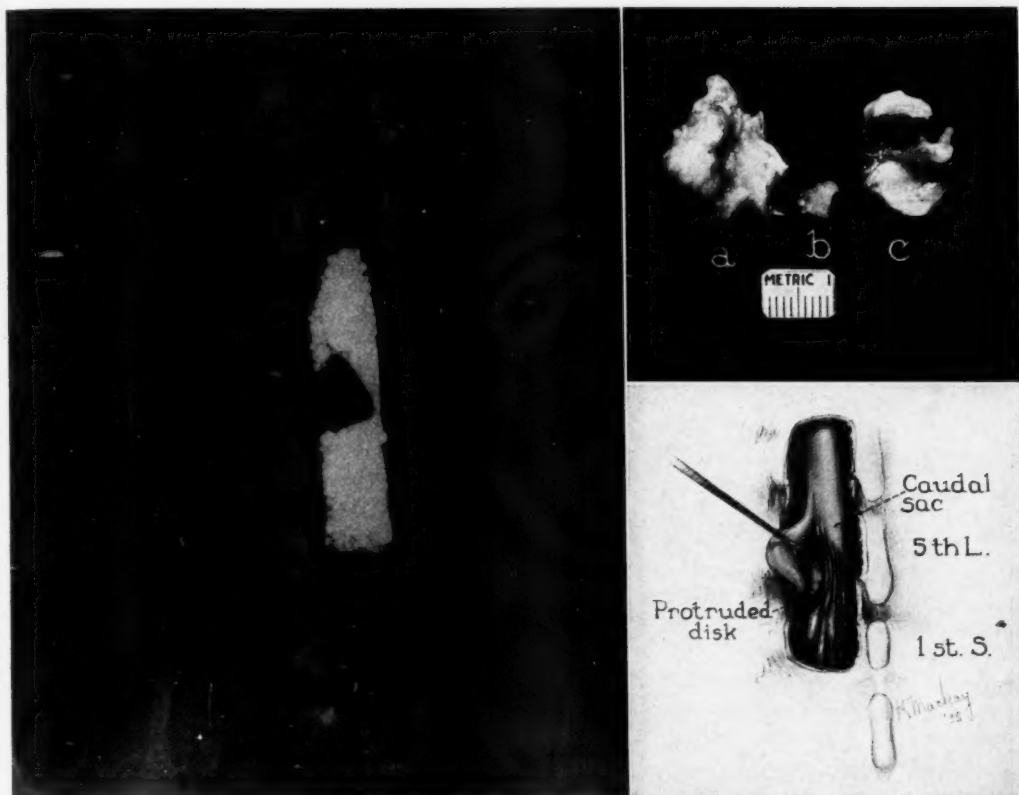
(left). Postero-anterior roentgenogram showing defect in the column of lipiodol opposite the third lumbar intervertebral space on the left. This defect is characteristic of protruded intervertebral disks. The patient had sustained an injury of his back a year and a half previously and had suffered backache and left sciatic pain since.
